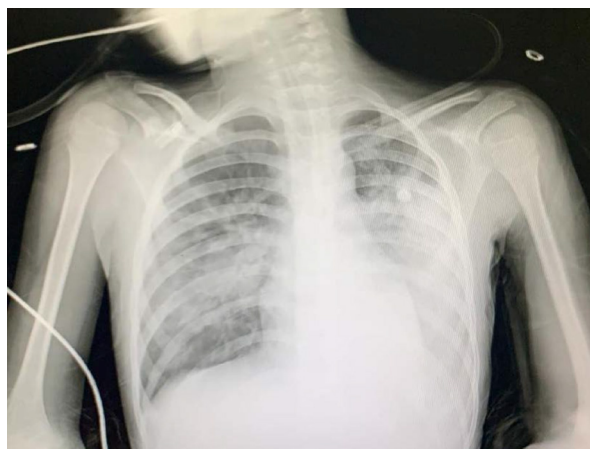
Chest radiography (anterior-posterior view) showing bilateral consolidation
